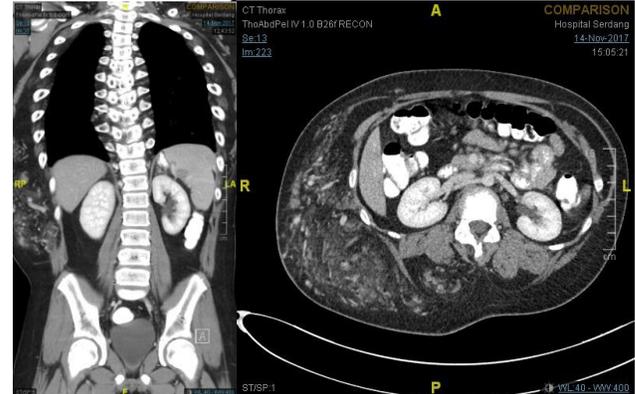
Computed tomography (CT) angiogram of thorax-abdomen-pelvis, showing diffuse truncal vascular malformation at posterolateral aspect of the right thoracolumbar region. No pleural or spinal canal extension detected. Scoliosis secondary to the mass.
